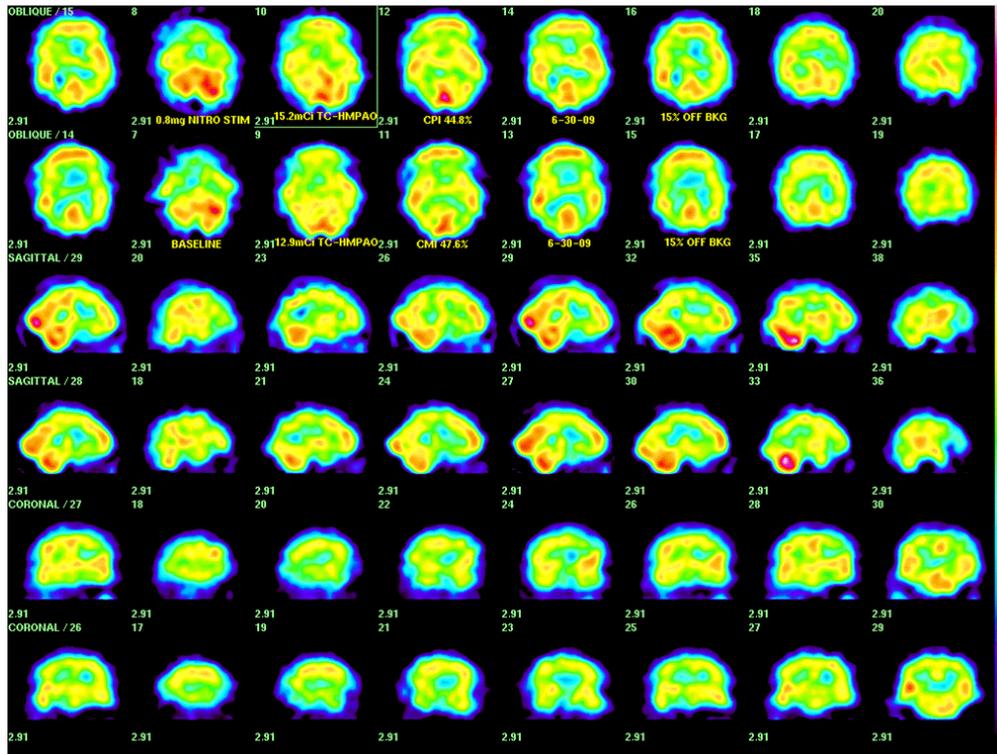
(above) A 65 year-old hypertensive, hyperlipidemic, hypogonadal man has also had episodes of traumatic brain injury and suffers from chronic low back pain requiring long term opiate therapy. Brain SPECT at the right shows hypothalamic hypometabolism, suspicious for pituitary disease and abnormal CFI = $(44.8 - 47.6)\% = -2.8\%$ (normal $> 1\%$). Although TYM or other neuropsychological testing is not available for this patient, his brain SPECT with bilateral parieto-occipital and temporal deficits in the basal study and more marked left fronto-parietal deficit in the perfusion-stimulated study suggests a mixed pattern of mild cognitive impairment. This is the most frequent pattern antecedent to dementia and raises issues of a cumulative risk factors contributing to eventual dementia.
